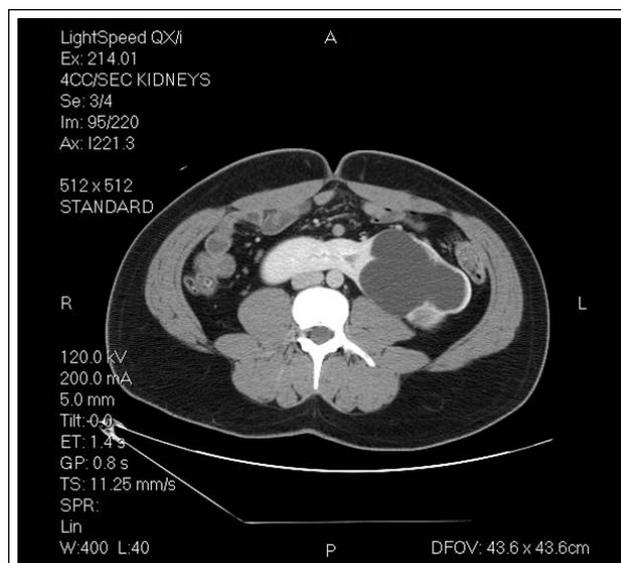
CT scan of the abdomen and pelvis with intravenous contrast used to delineate the renal anatomy and relationship to surrounding structures.
